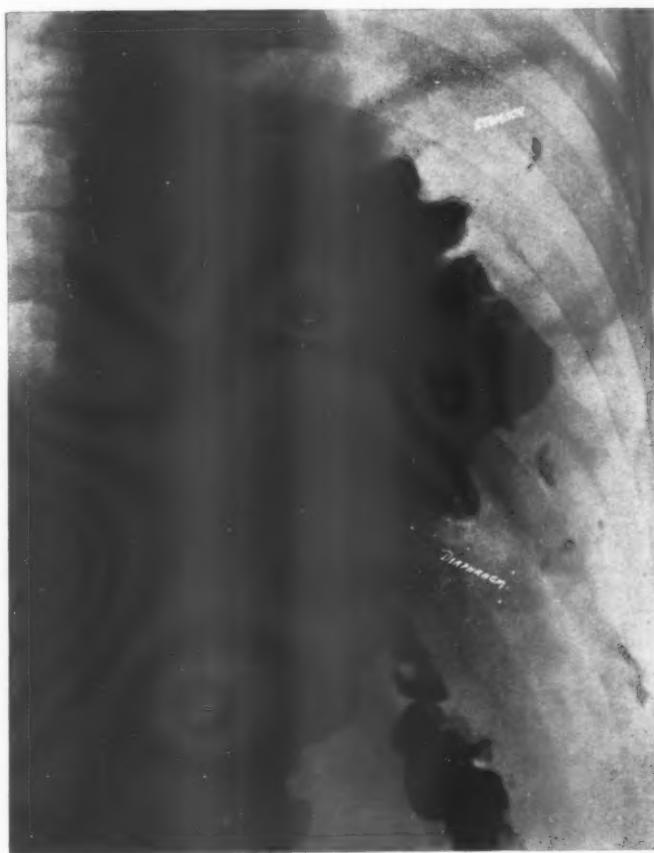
Radiograph with patient supine and feet elevated, showing the splenic flexure above the diaphragm.
